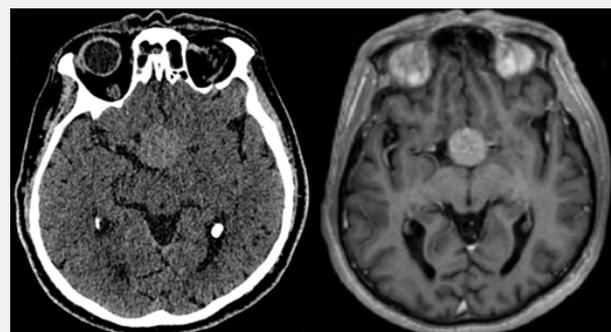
Treatment planning CT and MR images of a patient with pituitary adenoma.
